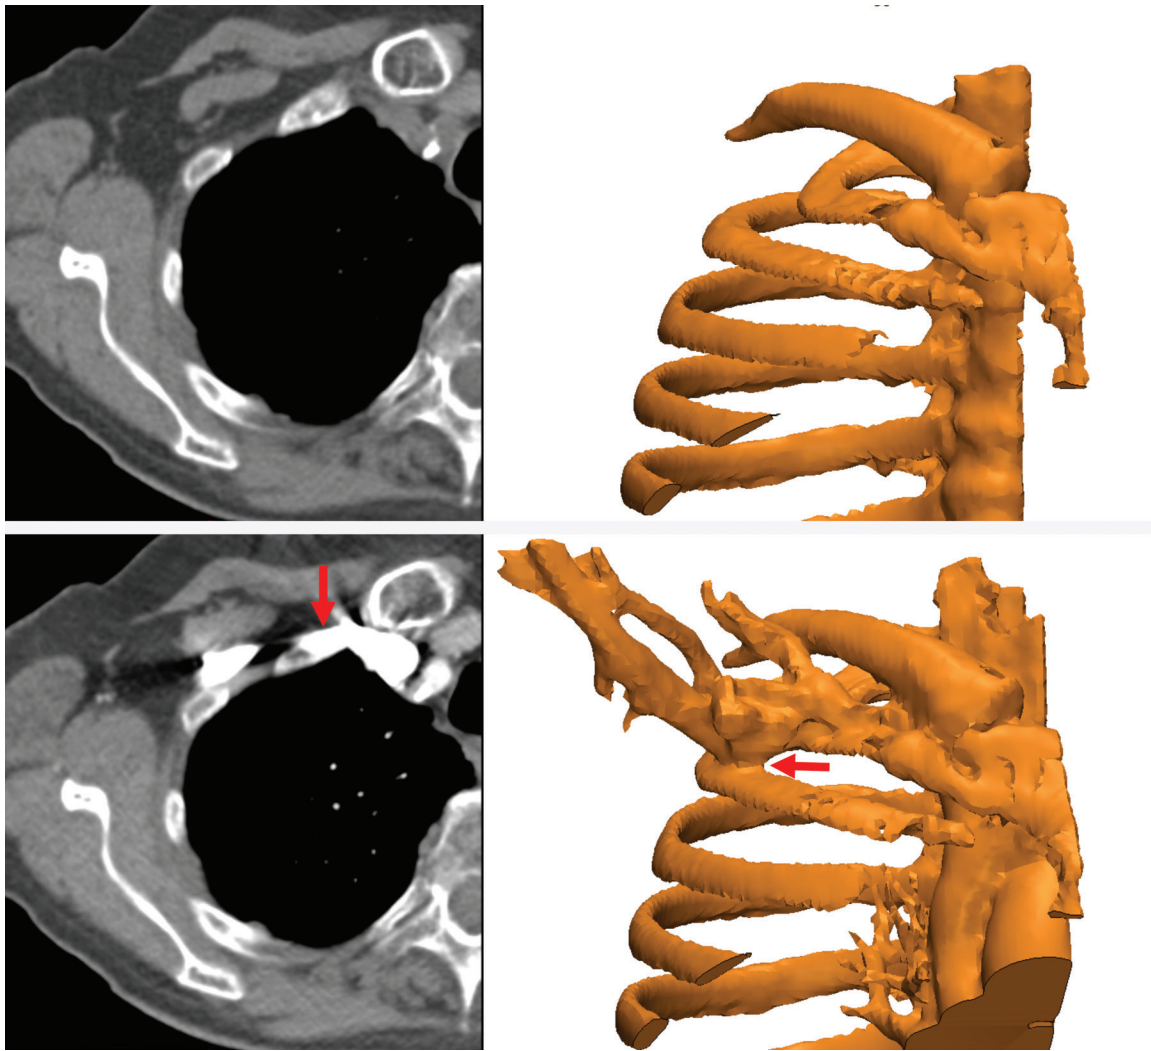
Segmentation complicated by contrast enhancement. Three-dimensional models of the ribs (right) were created from axial nonenhanced (top left) and contrast-enhanced (bottom left) CT images. The proximity of the subclavian vein, which is filled with high-density intravenously injected contrast material (bottom), precludes separation of the bone and vasculature (red arrows).
